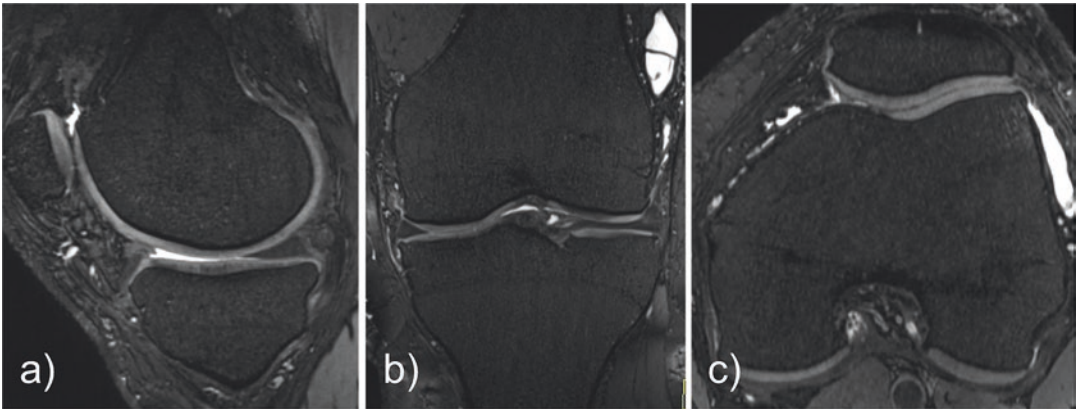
Morphological fat-saturated, proton-density turbo spin-echo (fsPD-TSE) MRI of a knee joint in three planes ((a): sagittal, (b): coronal, (c): axial). The images
